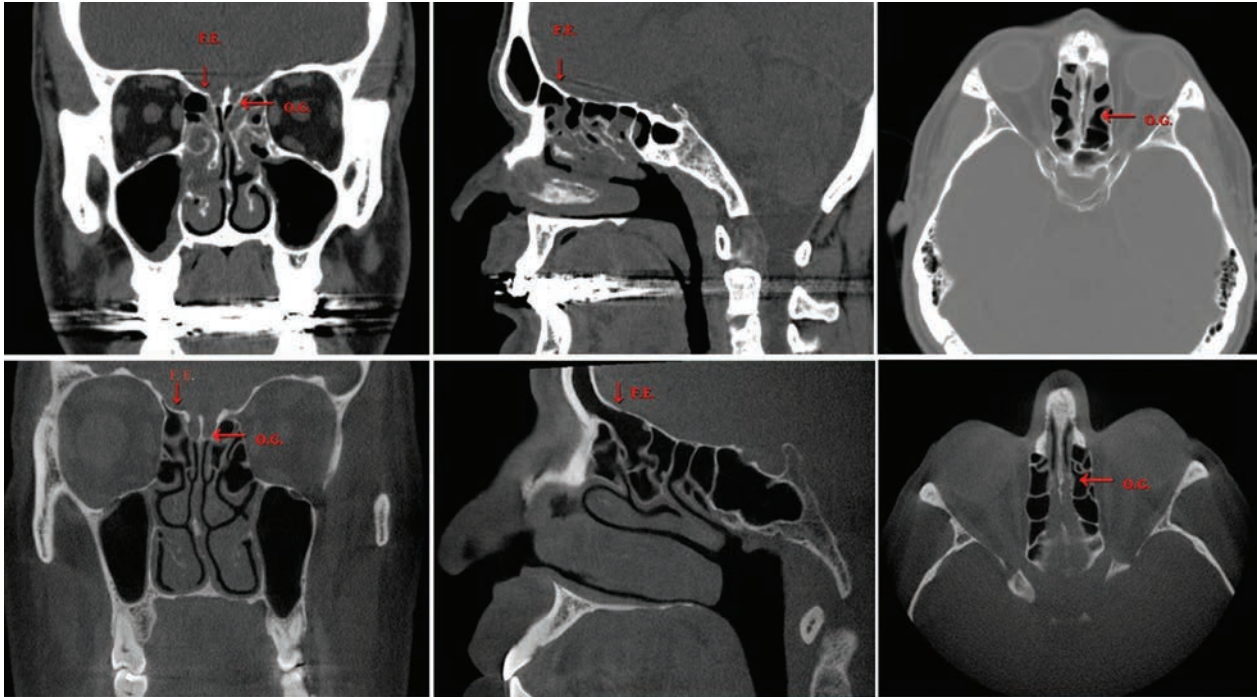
Coronal, sagittal and axial sections of standart-CT (up) and CBCT views of fovea ethmoidalis including olfactory groove
